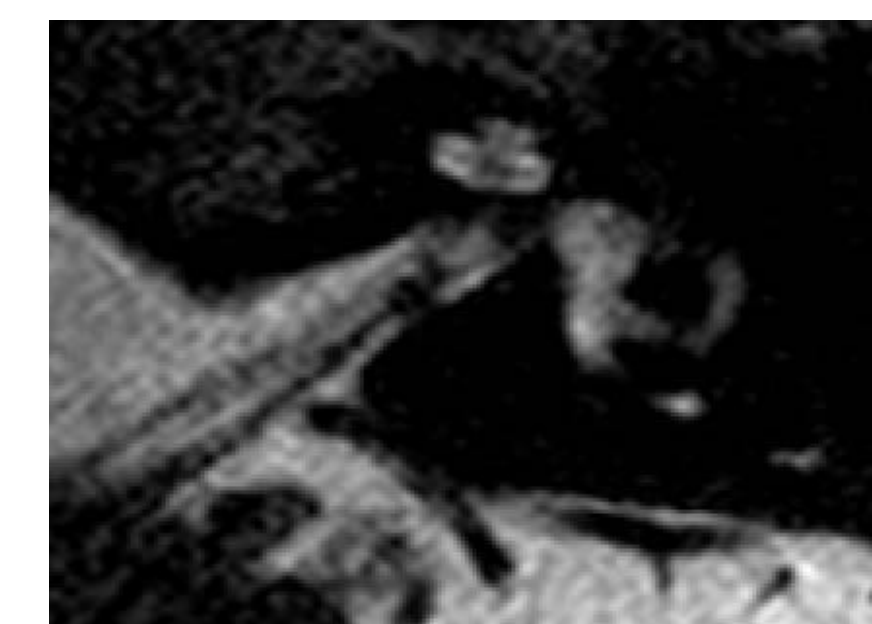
Representative image. Axial cut, magnetic resonance imaging, DRIVE sequence.
